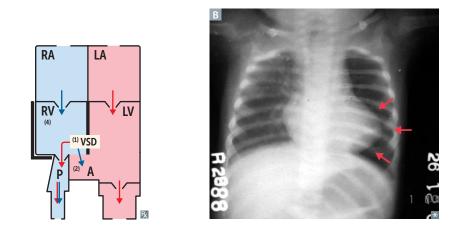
Tetralogy of Fallot. A Four concurrent defects: (1) Ventricular septal defect (VSD), (2) an overriding aorta, causing (3) right ventricular outflow obstruction (pulmonic stenosis) and subsequent (4) right ventricular hypertrophy. The extent of R-L shunting is determined by the degree of pulmonic stenosis present. B As seen on x-ray, the heart appears boot-shaped (arrows). (A, aorta; LA, left atrium; LV, left ventricle; P, pulmonary artery; RA, right atrium; RV, right ventricle.)
